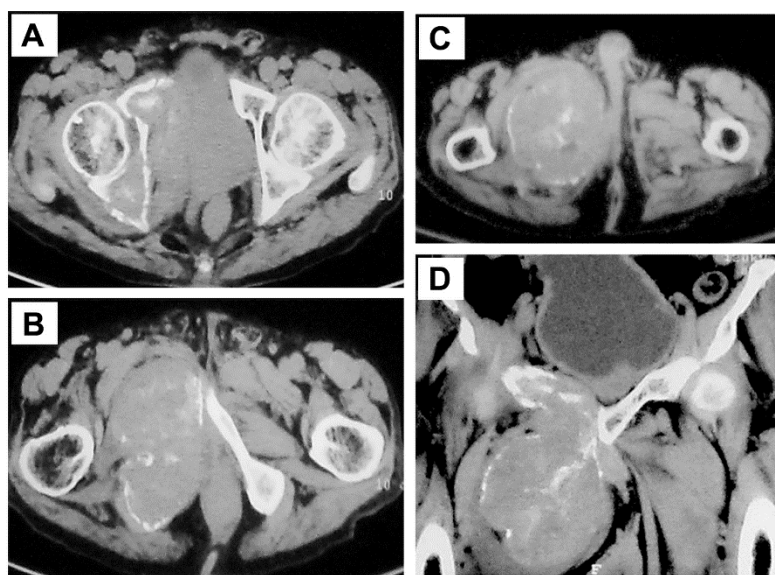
Panel A,B,C: Contrast CT axial images showing giant prostate cancer infiltrating the right lateral pelvic wall, femur and extending upto the mid-thigh deep to the muscle planes
